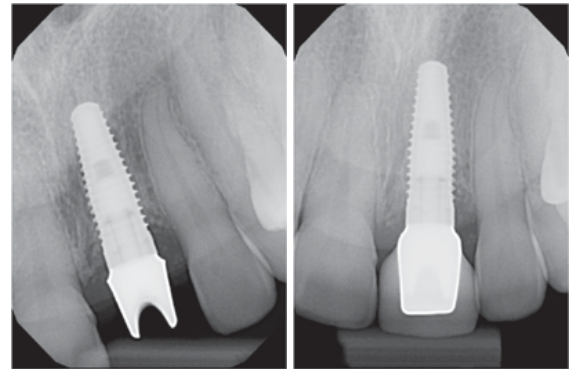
Periapical radiograph of the implant in position.
